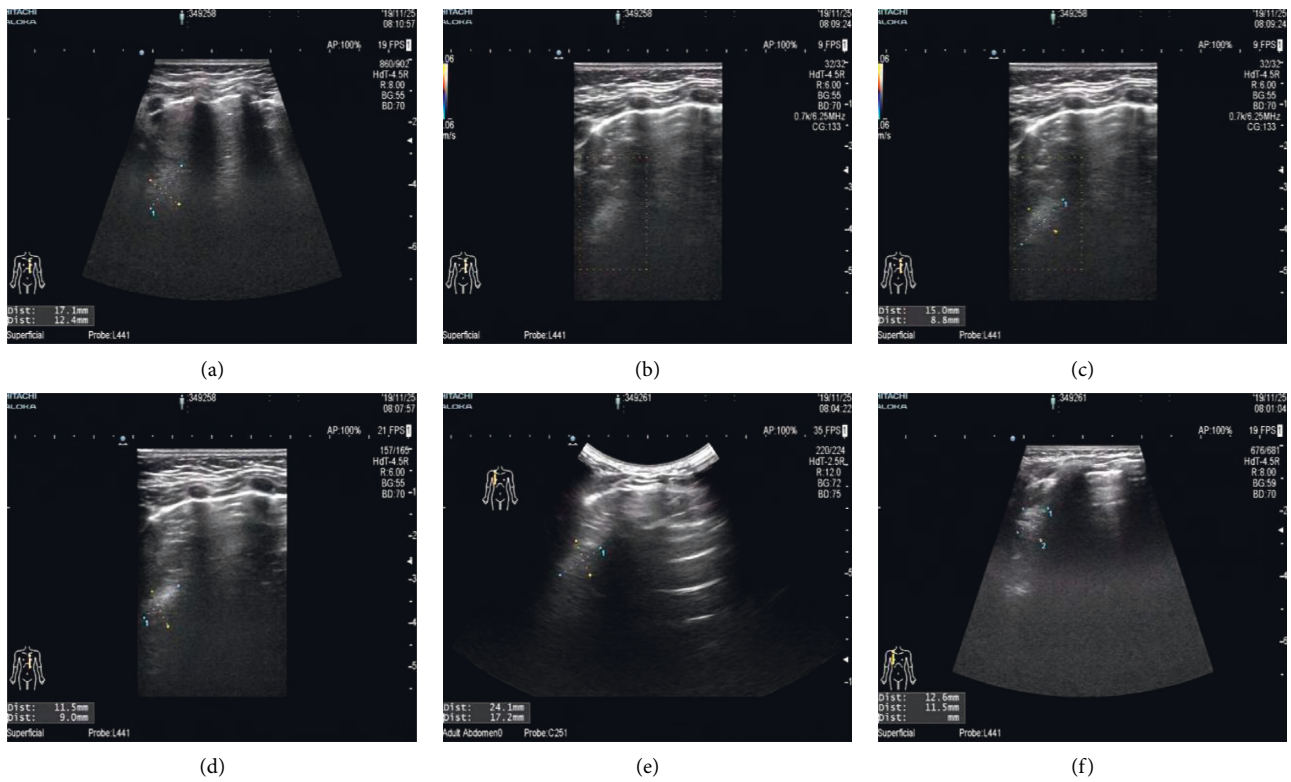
Ultrasound indicates irregular hyperechoic or mixed echo areas.
